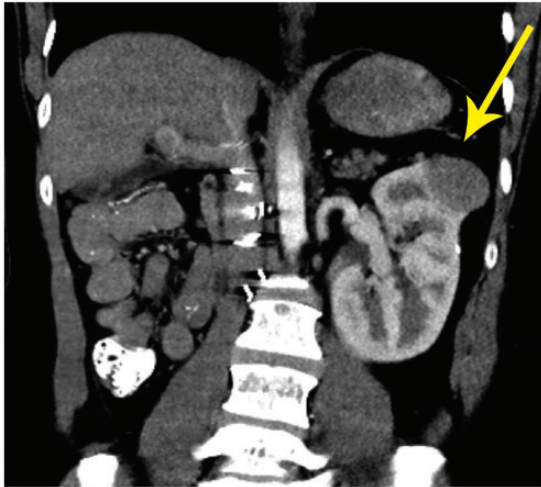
Coronal image from contrast enhanced CT of the abdomen/pelvis in portal venous phase – a partially exophytic solid mass seen arising from the superior pole of the left kidney. The left kidney is enlarged due to compensatory hypertrophy from prior right nephrectomy in the patient's childhood. The spleen is absent consistent with history of prior splenectomy.
